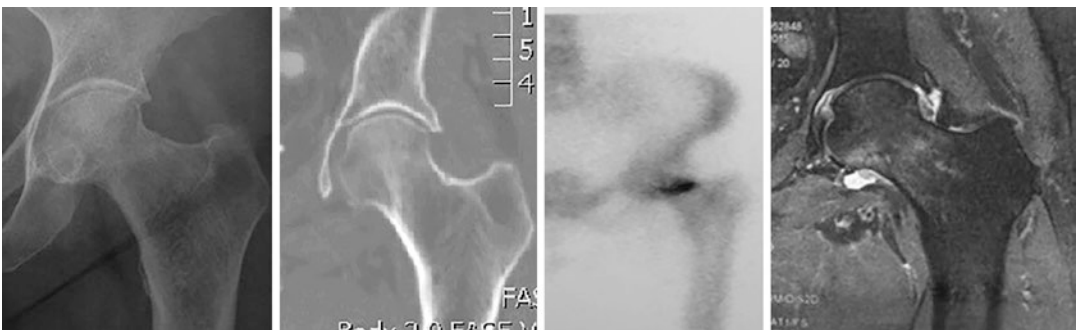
Stress fracture: x-ray, CT, scintigraphy, and MRI
